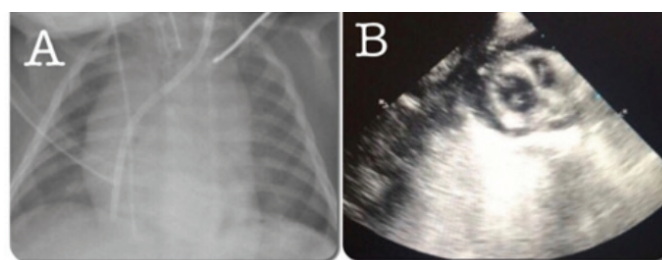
A) Chest X-ray showing a markedly enlarged cardiac silhouette and mediasten. B) The echocardiographic showing large pericardial effusion with cardiac tamponade
